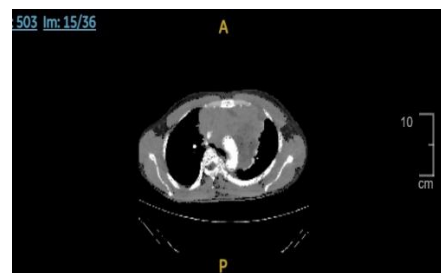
CT Scan Thorax demonstrates compression of SVC
